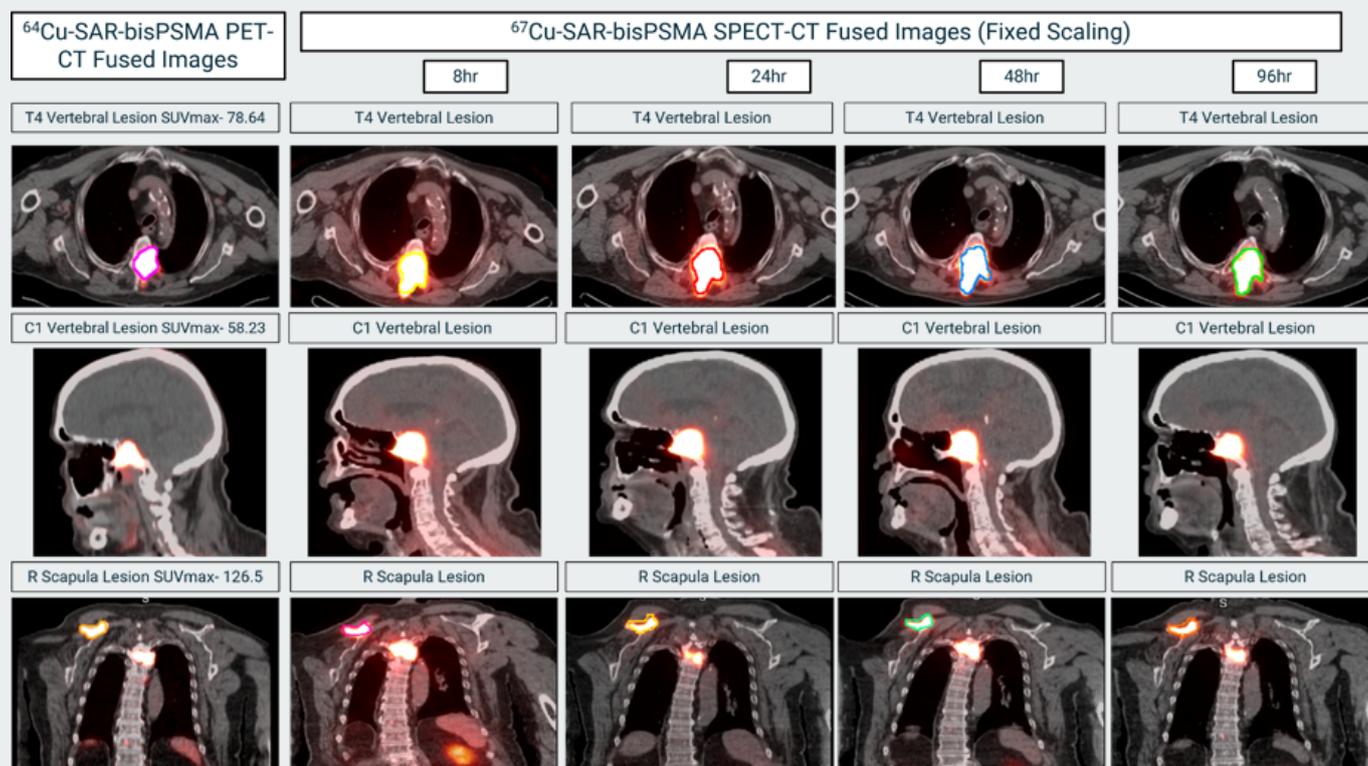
Comparison of <sup>64</sup>Cu SAR-bisPSMA and <sup>67</sup>Cu SAR-bisPSMA imaging. PET, SPECT, PET-CT and SPECT-CT images of the same patient administered with the diagnostic agent (<sup>64</sup>Cu-SAR bisPSMA) followed by the therapeutic agent (<sup>67</sup>Cu SAR-bisPSMA). The coloured arrows show examples of the same areas of disease being targeted by both the diagnostic and therapeutic agents.
